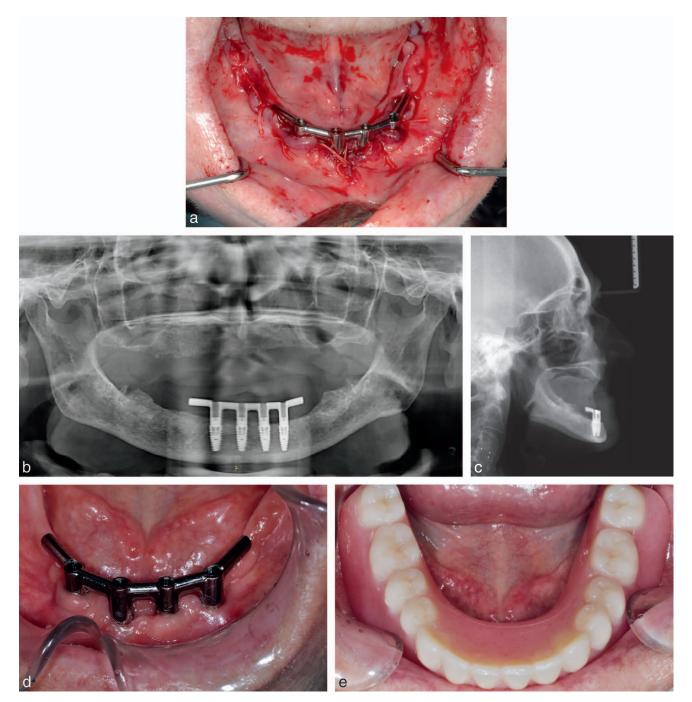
Postoperative clinical and radiographic images. (a) Frontal view of the mandibular arch with the retention bar after primary closure. (b) Panoramic view demonstrating the 4 implants and the retention bar in the interforaminal region. (c) Lateral cephalogram. (d) Frontal view of the mandibular arch with the retention bar. (e) The implant-retained overdenture 6 weeks postoperatively.
